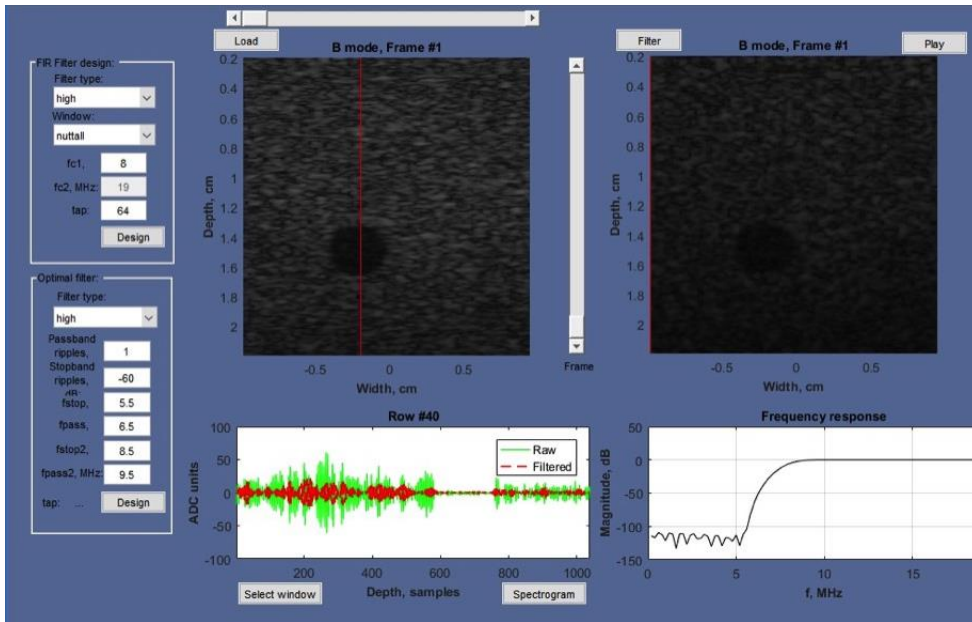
Example GUI for Ultrasound Imaging [15]
